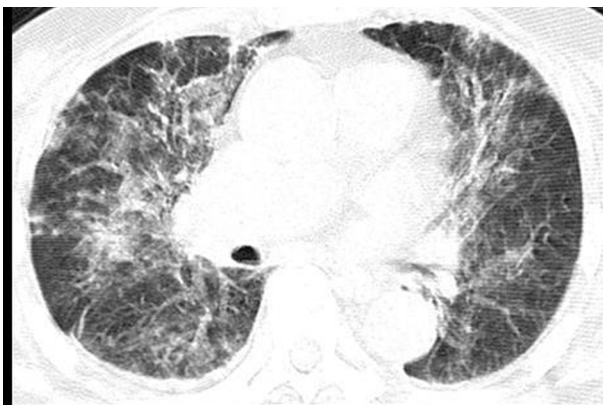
CT of the chest showed sparsely distributed ground-glass alveolar opacities with patchy consolidation.
